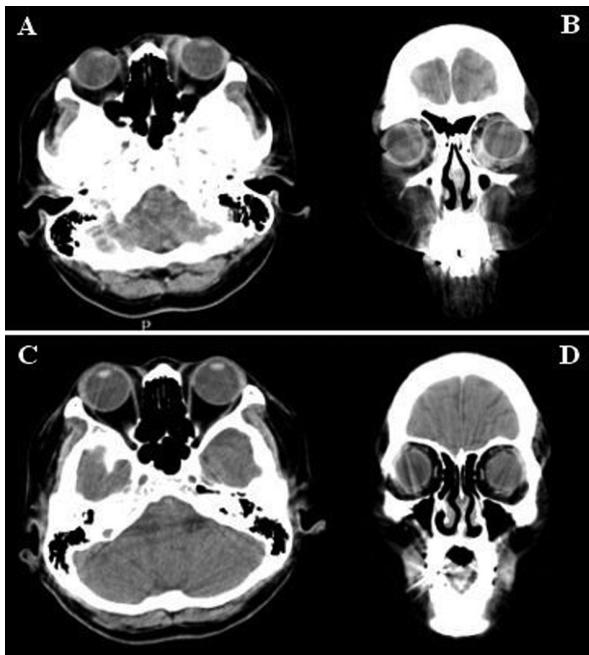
A and B, Orbital CT scan revealed an ill-defined soft tissue density mass at the medial aspect of the left orbit on both axial and coronal views. C and D, Five months after incisional biopsy, the follow-up orbital CT scan demonstrated complete regression of the tumor.
